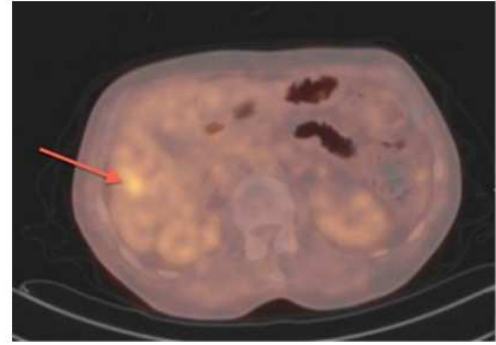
Preoperative PET-CT scan shows segment 6 metastases in the liver (Red arrow shows metastasis).
